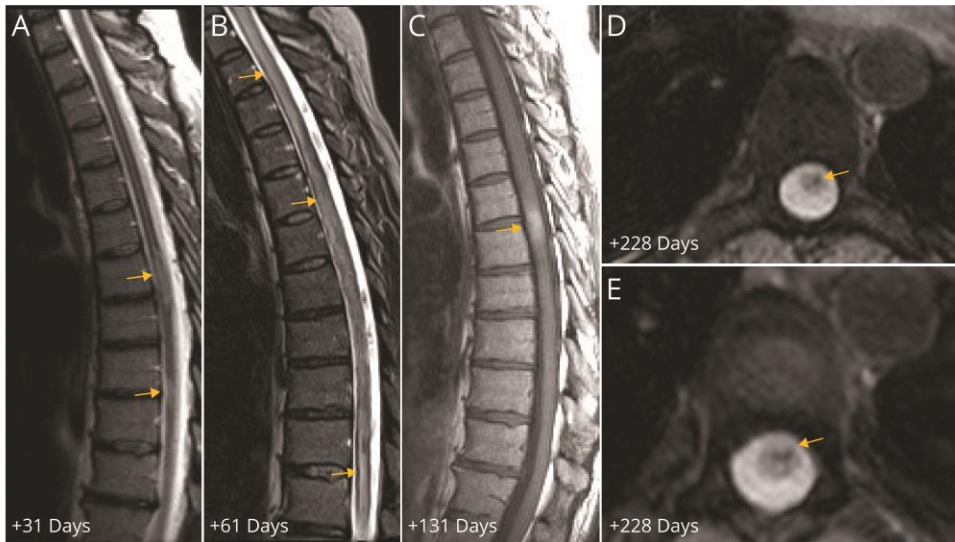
Progression of MRI changes for Case 2 (A-E) and Case 3(F-J).
